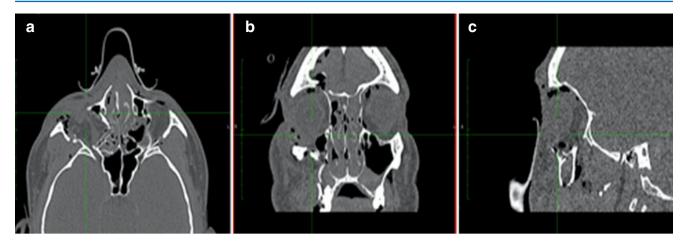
CT assessment starts with visualisation of the scan in the axial plane (a). The scans are viewed serially cranial to caudal. This allows accurate assessment of the anteroposterior projection of midface and facial width. Fracture extension into the orbital floor is best assessed in the coronal plane (b). Sagittal views define the anterior and posterior margins of the orbital floor injury (c). Note the extensive right orbital floor component
